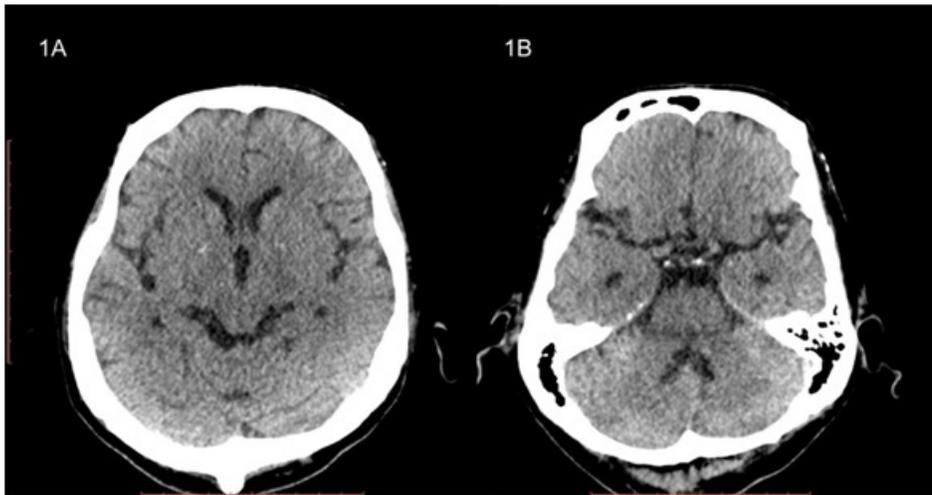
& 1B: Initial head computed tomography (CT) did not show any acute infarct or haemorrhage
